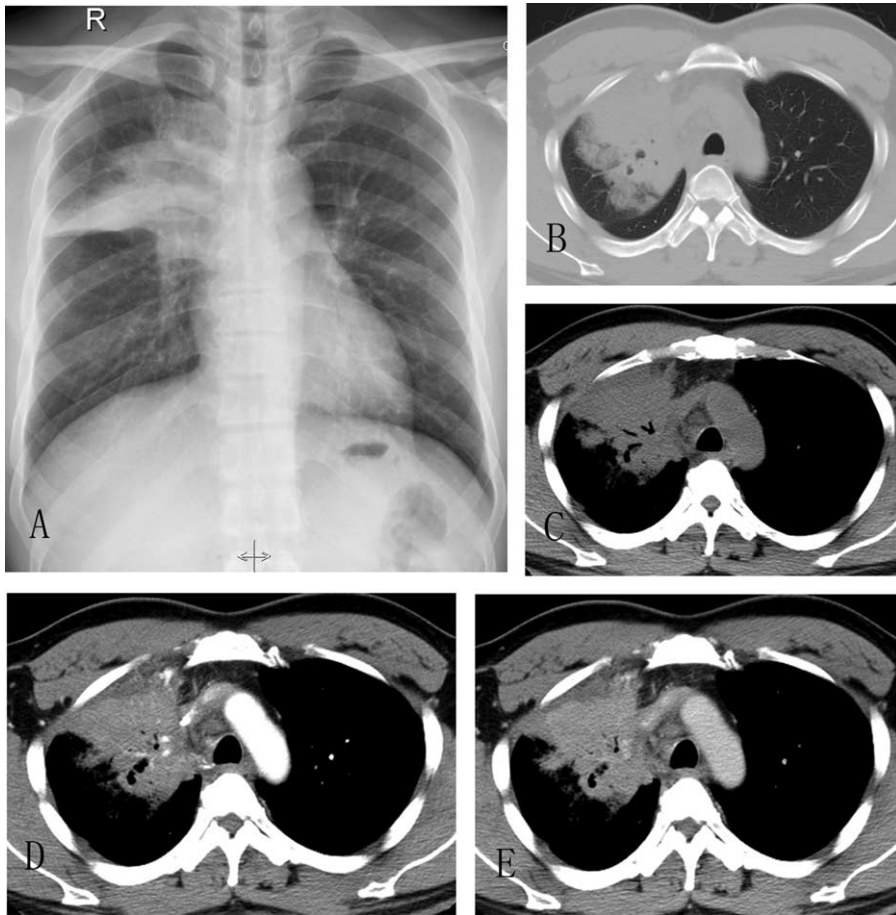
(A) Chest radiograph showing a mass of 8.9×6.7 cm. After 6 months, computed tomography scan images for a 8.3×7.2 -cm-sized, homogeneous enhanced irregular mass on the right upper lobe and 1.2×1.1 -cm-sized lymph node in the mediastinum were observed (B, lung setting view; C–E, mediastinal window view).
